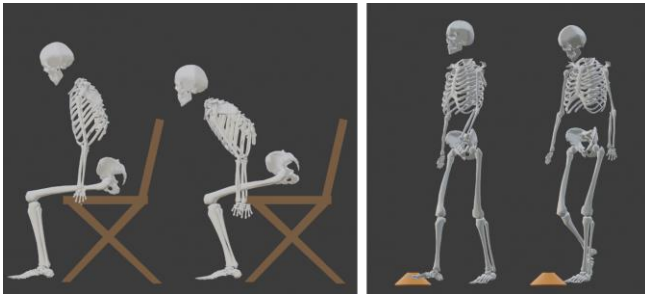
Unrestricted and restricted head-trunk locking variations of the functional tasks. Left: S2S. Right: CT.
